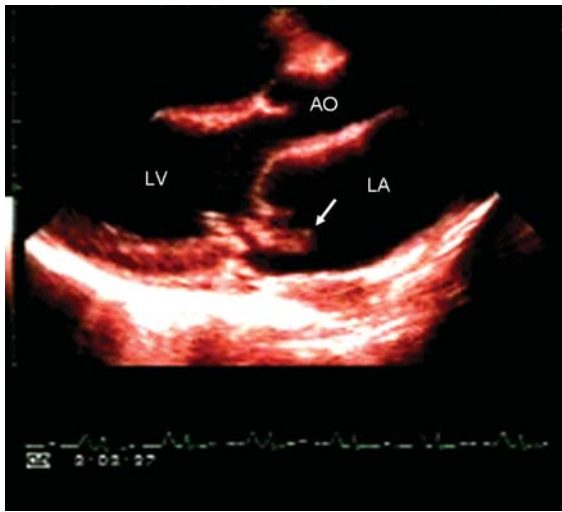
Transthoracic echocardiogram parasternal long-axis view showing a mass attached to the tip of the anterior mitral valve leaflet (white arrow) with severe anterior leaflet prolapse consistent with flail mitral valve. AO, ascending aorta; LA, left atrium; LV: left ventricle.
